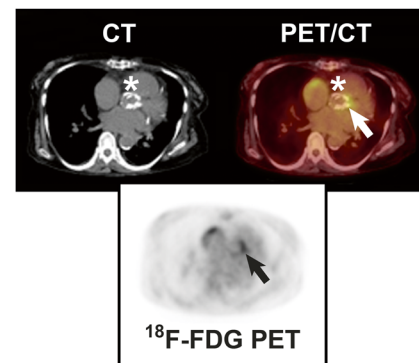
^{18}F -FDG PET for the assessment of prosthetic valve endocarditis. Abnormal ^{18}F -FDG uptake (arrow) is shown around a prosthetic aortic valve (white star), which suggests the presence of prosthetic valve endocarditis. Abbreviations as in Figs. 1, 2, and 3
